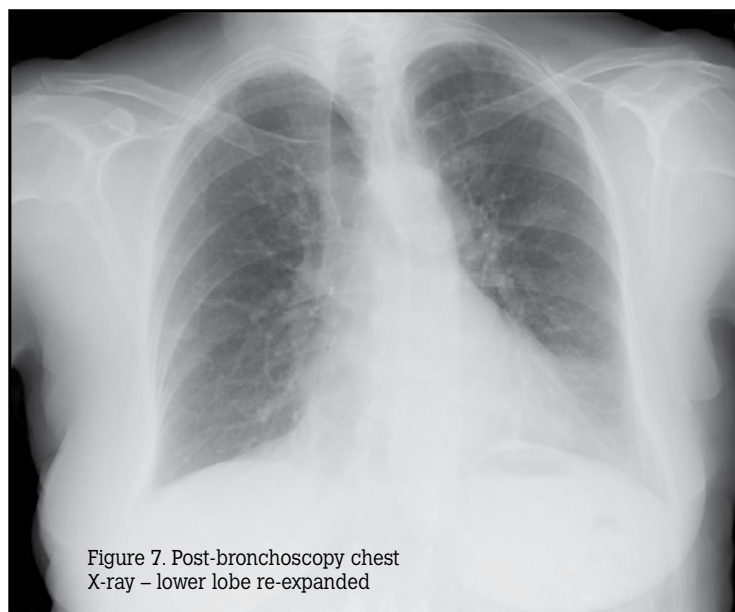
Post-bronchoscopy chest X-ray – lower lobe re-expanded
